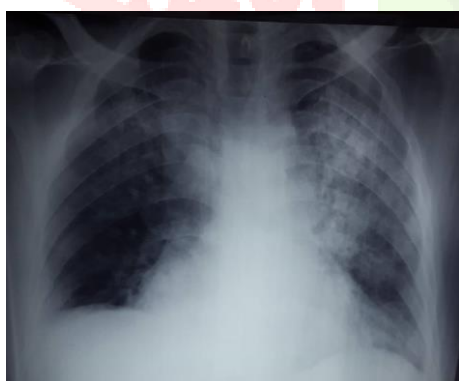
Chest X-ray demonstrating a bilateral interstitial edema
